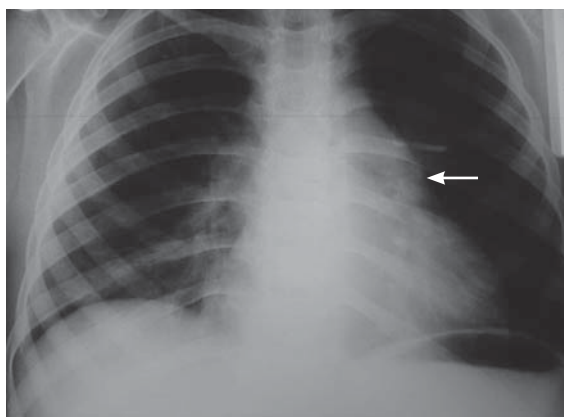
A chest radiograph showed a superior mediastinal enlargement.
